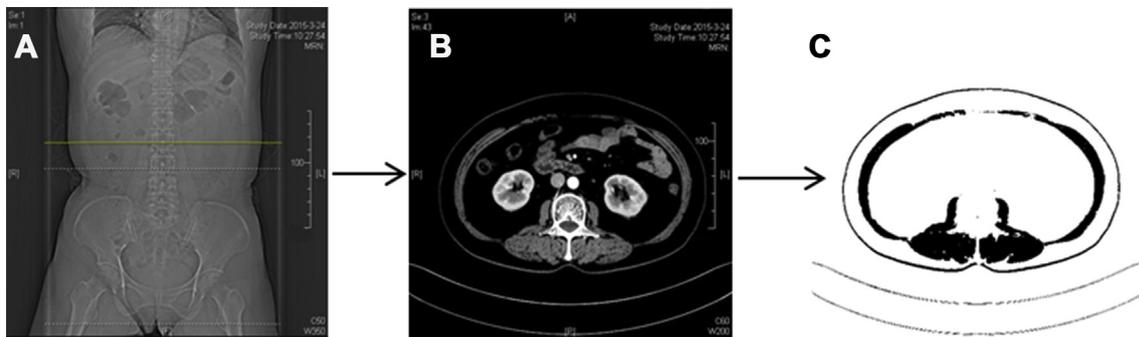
Assessment of skeletal muscle mass by computed tomography. A, Two cross-sectional computed tomography images were selected to measure the areas of the skeletal muscles at the level of the third lumbar vertebra. B, After identifying individual vertebral levels, we then selected the individual imaging slice at the median aspect of the third lumbar vertebra and outlined the borders of the skeletal muscles. C, The area of the resulting regions within a range of -29 to $+150$ hounsfield units was then computed to calculate the total skeletal muscle area.
